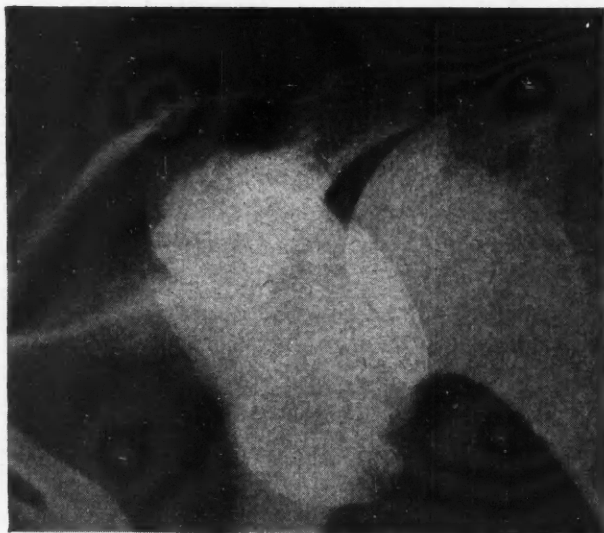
X-ray showing the false joint in the subluxated position. Also the posterior notch from recurrent dislocations.
